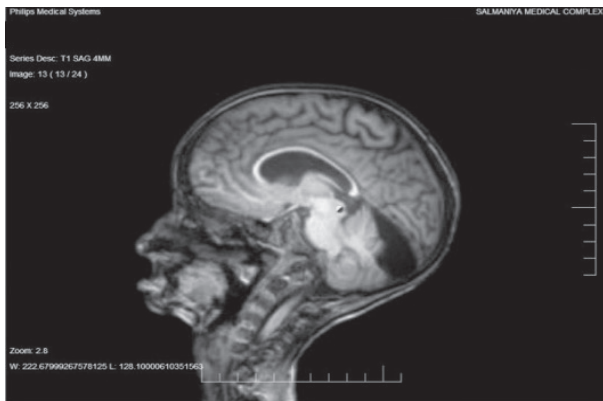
Brain MRI Showing Evidence of Empty Sella Syndrome
